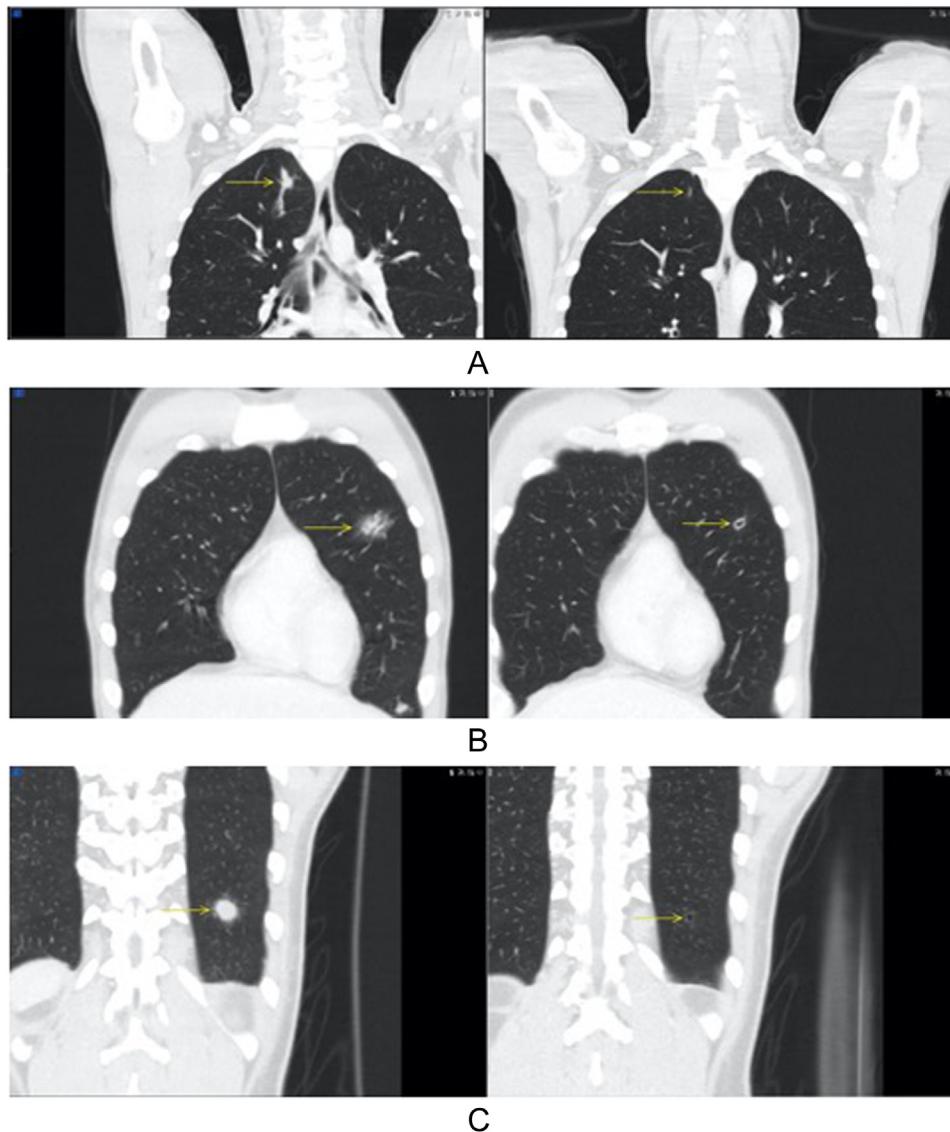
Initial CT scans of the thorax after early antibiotic commencement compared to repeat CT scans after 6 weeks of treatment, demonstrating significant regression of infiltrates (arrows) and development of small areas of cavitation. (A) Shows an infiltrate located in the upper lobe of the right lung (first segment). The infiltrate was significantly reduced in size. (B) Shows an infiltrate located in the upper lobe of the left lung (fourth segment). The infiltrate was partially reduced in size with cavitary formation. (C) Shows an infiltrate located in the lower lobe of the left lung (10th segment). The infiltrate was significantly reduced in size with cavitary formation.
